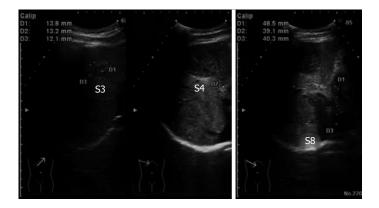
Ultrasonography of the abdomen. All of the tumors showed hypo- or isoechoic heterogeneous masses without halos.
